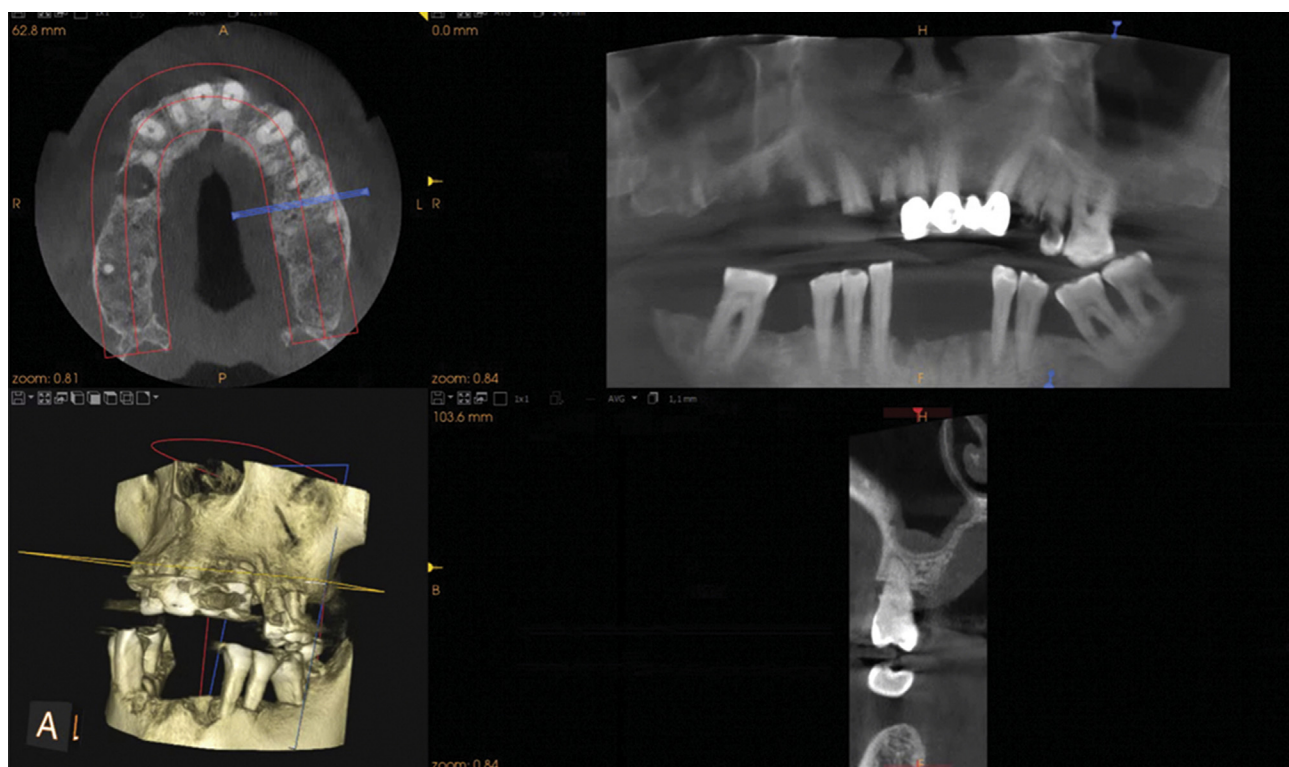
Cone beam computed tomography (CBCT) scan.
